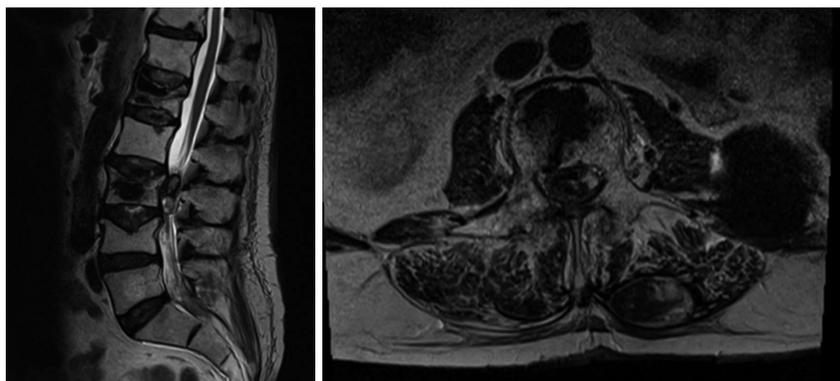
T2 weighed magnetic resonance imaging of the lumbar tract of the spinal column on sagittal and axial planes. The images reveal the presence of a lesion located within the spinal channel at L2-L3. It is not possible to establish if it is located within the intradural or extradural space by the mere observation of the MRI. Note the needle trajectory inside the spinal channel at L1 on the right side.
